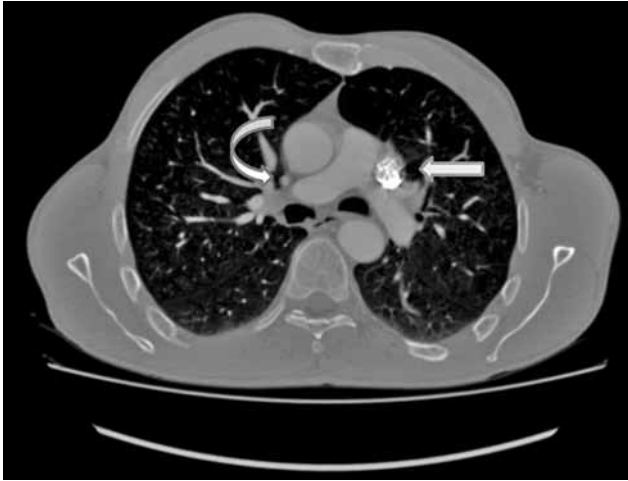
Computed tomographic image showing the absence of the right superior vena cava (curved arrow) and the dilated left superior vena cava (arrow).
